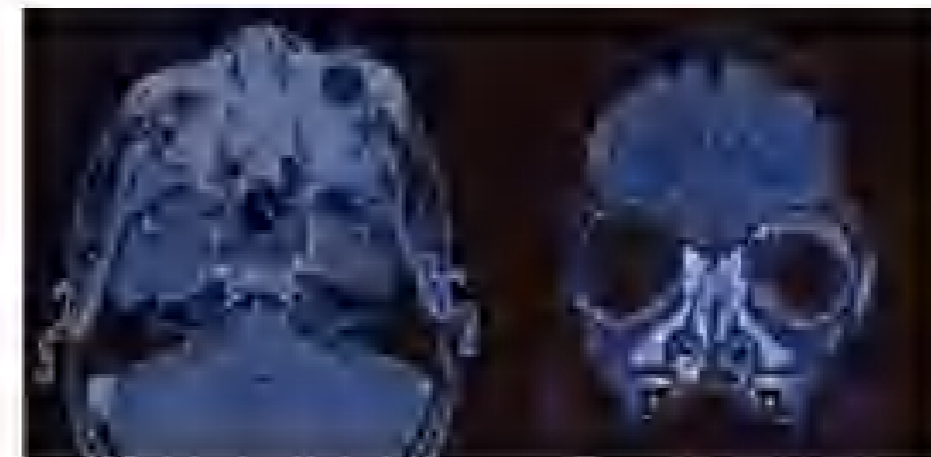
Magnetic resonance imaging of the orbits with and without contrast was obtained, demonstrating mass-like infiltrative enhancement involving both extraocular orbits (left greater than right).
